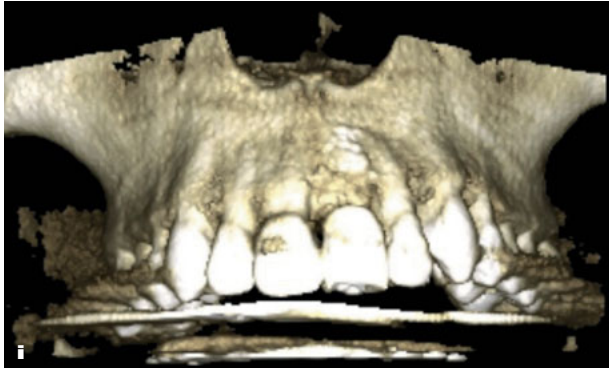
(continued) (i and j) Cone beam computed tomography (CBCT) analysis of the site before implant insertion. (k and l) Buccal and occlusal views of the site preoperatively. (m) Microflap overlapping the surgical guide with the first drilling bur. (n) Drilling bur highlighting the midcrestal, buccally inclined positioning. (o) Implant insertion. Note the convergent shape of the collar.
